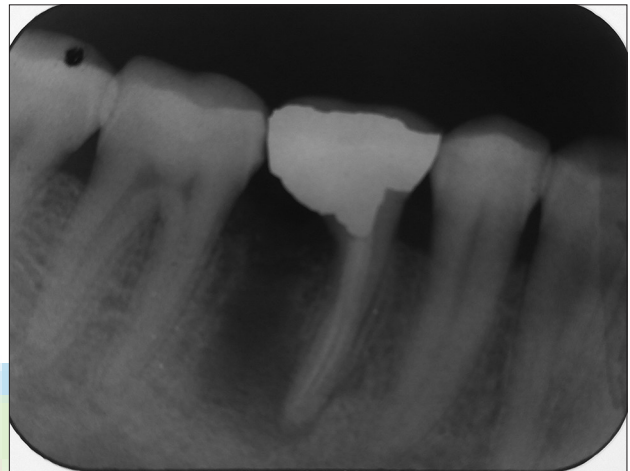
Preoperative radiograph of mandibular right first molar
